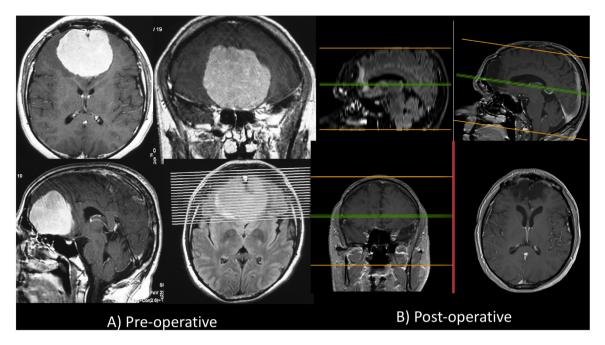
(A) Pre-operative MRI: 3 planes post-Gd T1-weighted images, demonstrating intense enhancement of the meningioma and axial FLAIR image (lower right), showing peritumoral edema. (B) Post-operative MRI: Sagittal FLAIR image (upper left) and post-Gd T1-weighted images in 3 planes, confirming the total excision of the mass and showing findings consistent with porencephaly and gliosis of the medial prefrontal cortex, anterior cingulate gyrus, as well as the cingulum and anterior part of corpus callosum.
